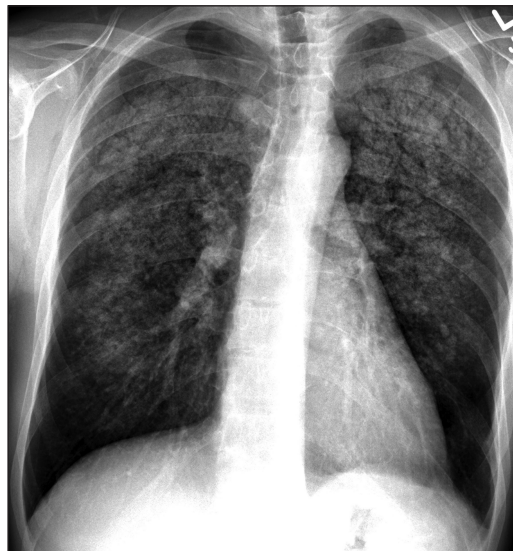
Chest radiograph of a 37-year-old man with chronic renal failure and nonproductive cough, showing ground glass opacities.
